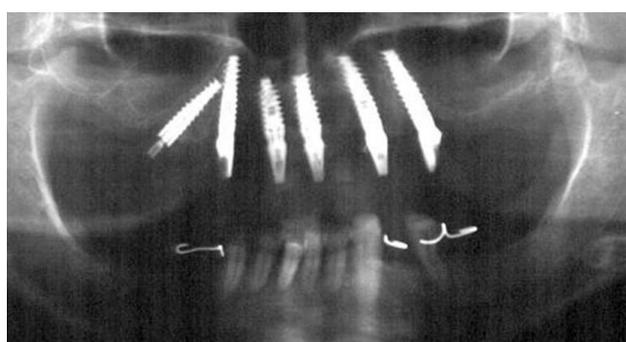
Post-surgical panoramic radiographs
